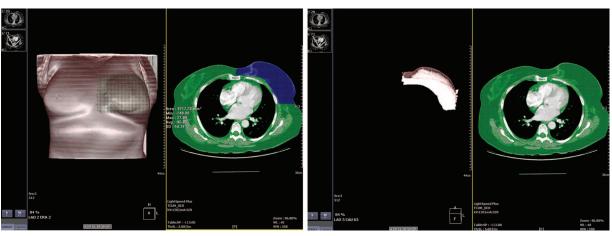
The authors' methods for measuring breast volume. (*Left*) The borderline of the breast is selected in each axial computed tomographic section. (*Right*) Several selected sections of the axial view were reconstructed as a three-dimensional image. The image shows the basal view of the three-dimensionally reconstructed breast.
